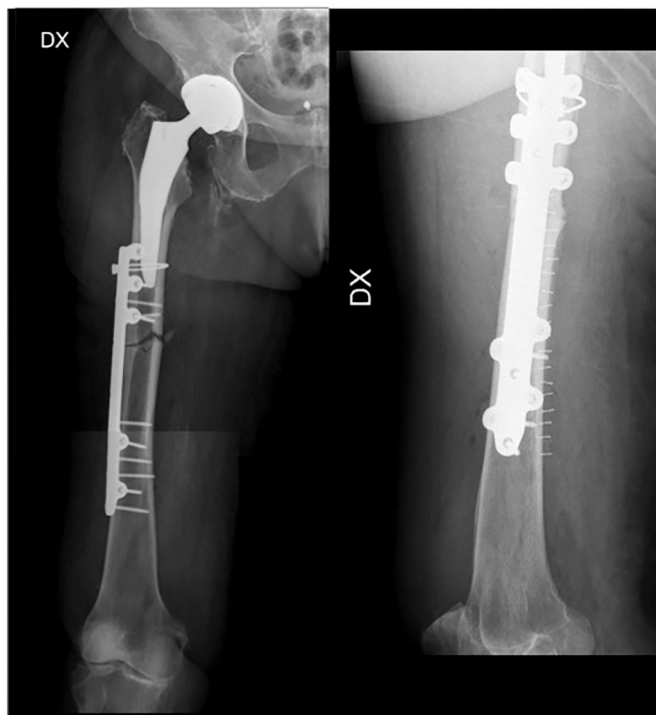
Immediate post-operative radiographs demonstrating open reduction and internal fixation of periprosthetic atypical fracture. Right: antero-posterior right femur. Left: lateral right femur.
